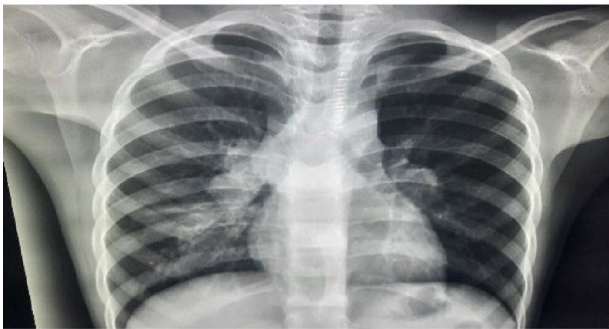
Chest X-ray showing perihilar lymphadenopathy.
